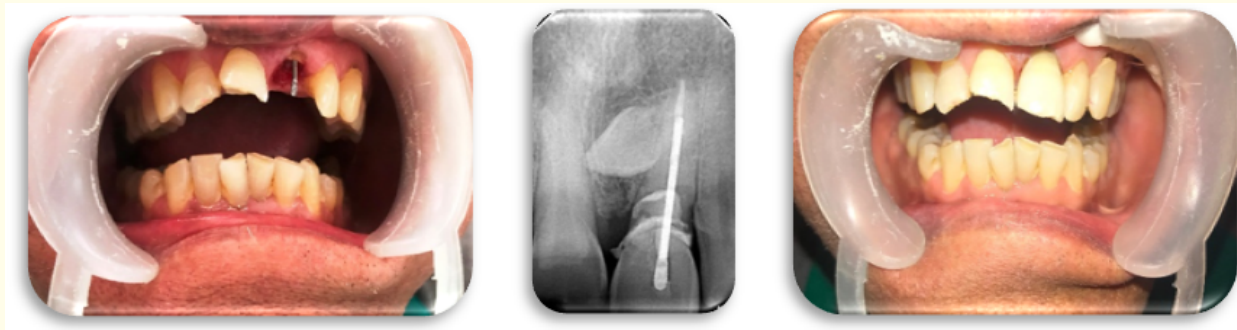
A) Placement of post B) Postoperative radiograph C) Postoperative photograph after reattachment.
